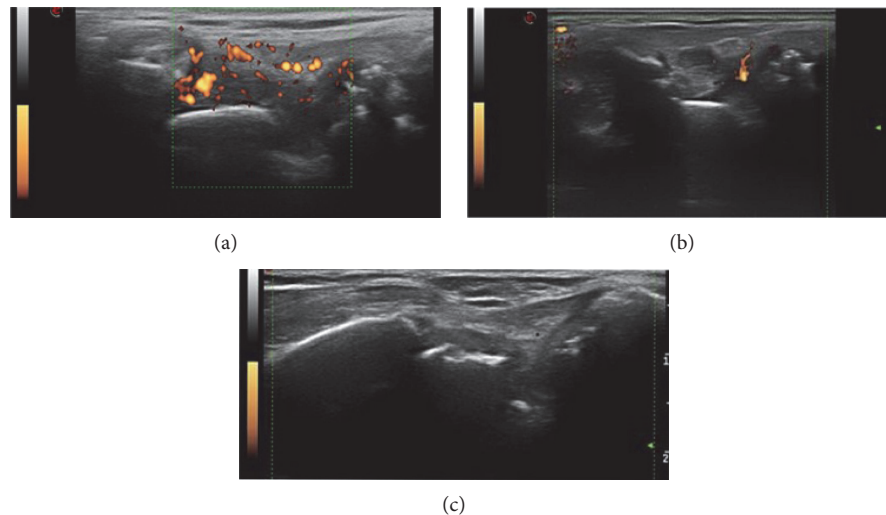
Serial changes after adalimumab therapy at radio-lunate joint (a) baseline (0 month, SH grade 3, SV grade 3), (b) one month (SH grade 3, SV grade 1), and (c) three months after (SH grade 1, SV grade 0). Power Doppler synovitis decreased dramatically on the first month, while gray scale synovitis decreased from the third month.
